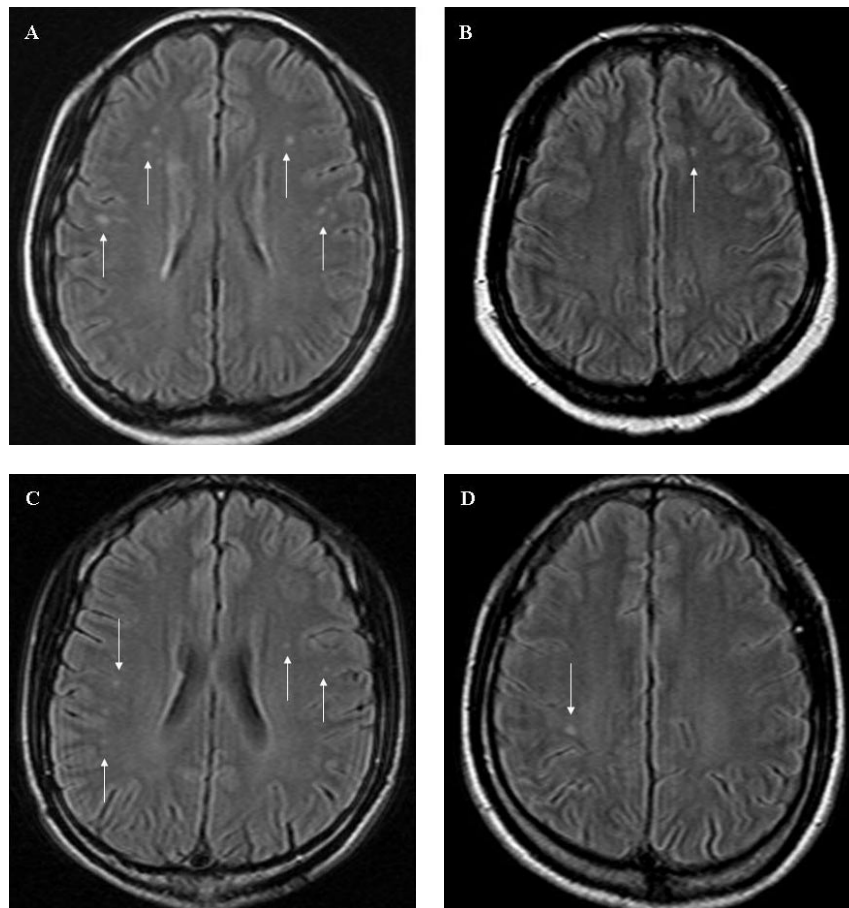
Transverse FLAIR brain MRI images in patients with *MFN2* mutations. (A) FC169 (III-4) with transient dysarthria and migraine displayed multiple non-specific but definitely pathogenic subcortical hyperintense lesions. (B) FC188 (II-2) having a transient right upper limb and facial sensory loss of 1 month's duration showed T₂ and FLAIR high-signal intensities without abnormal enhancements. (C) FC81 (III-3) with H165R showed SNHL and displayed multiple subcortical white matter lesions that could not be attributed to age. (D) FC169 (III-7) with R280H showed extensor plantar responses and also demonstrated a non-specific but pathogenic hyperintense lesion.
